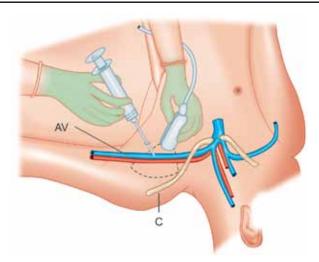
In-plane technique: The position of ultrasound transducer to obtain a longitudinal image of axillary vein and the needle is advanced in plane to reach the vein to puncture it (AV: Axillary vein; C: Clavicle)
